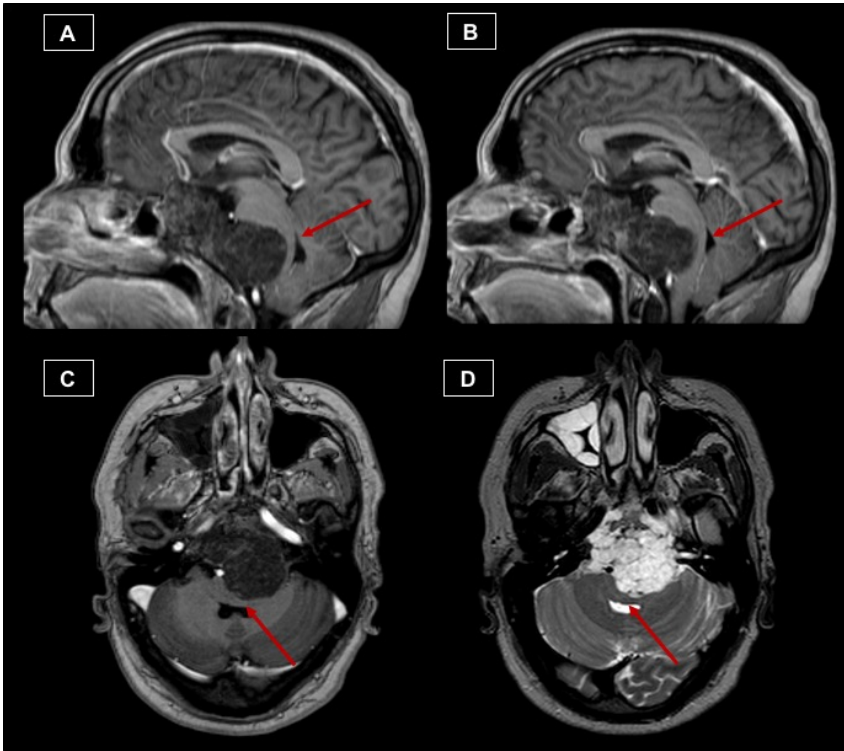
Sagittal (A, B) and axial (C) T1-weighted post-contrast and axial T2-weighted (D) MR images showing chordomas dislocating the brainstem.
